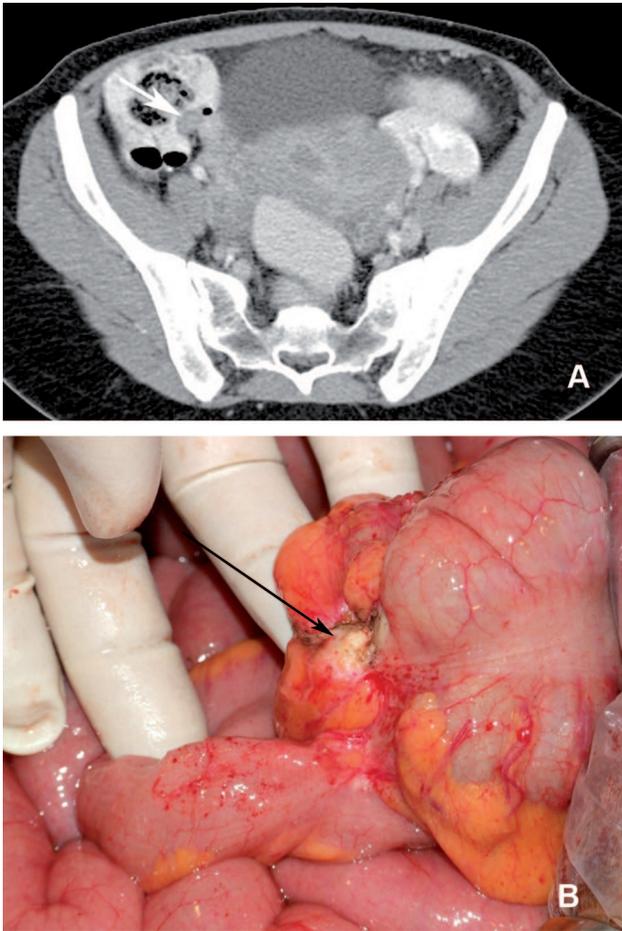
A, Radiologic CT scan (white arrow) and (B) surgical views of caecal endometriosis (black arrow) treated by wedge resection.
